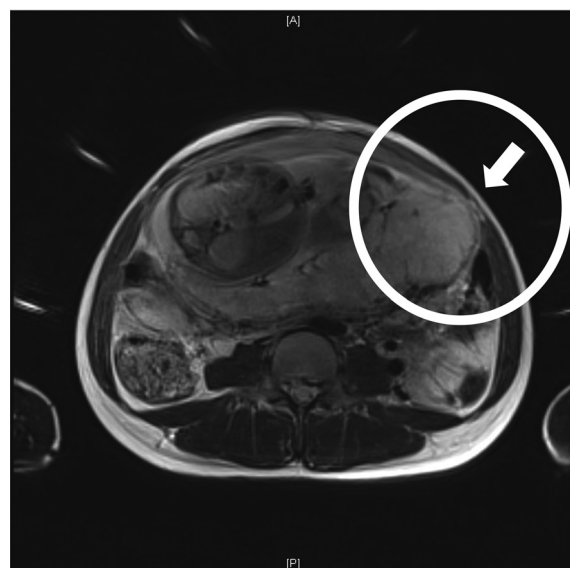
Coronal T2-weighted MRI at 30 weeks showed that the placenta was mainly located on the left fallopian tube angle. Because of the location of placentation with Figure 1, the uterine wall was extruded toward the left fallopian tube (circle). The MRI also showed a loss of continuity of the uterine wall (arrow), suggesting the presence of unexpected PAS.
